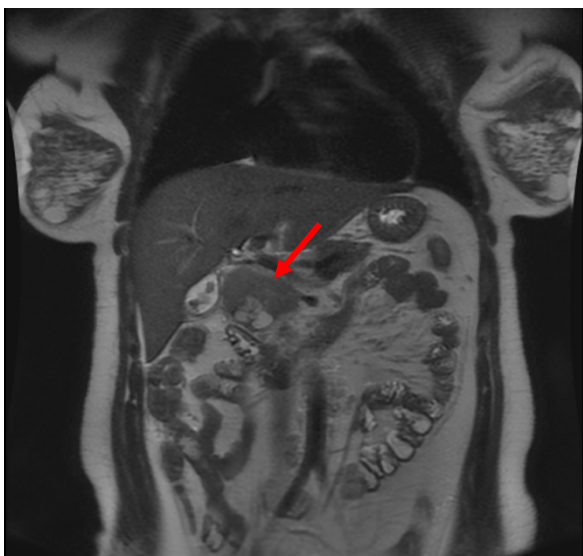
Coronal section of MRI done at 5 weeks gestation showing the 4.9 x 4.6 cm (TV x AP) well defined ampullary mass appearing as mixed with cystic and solid components
